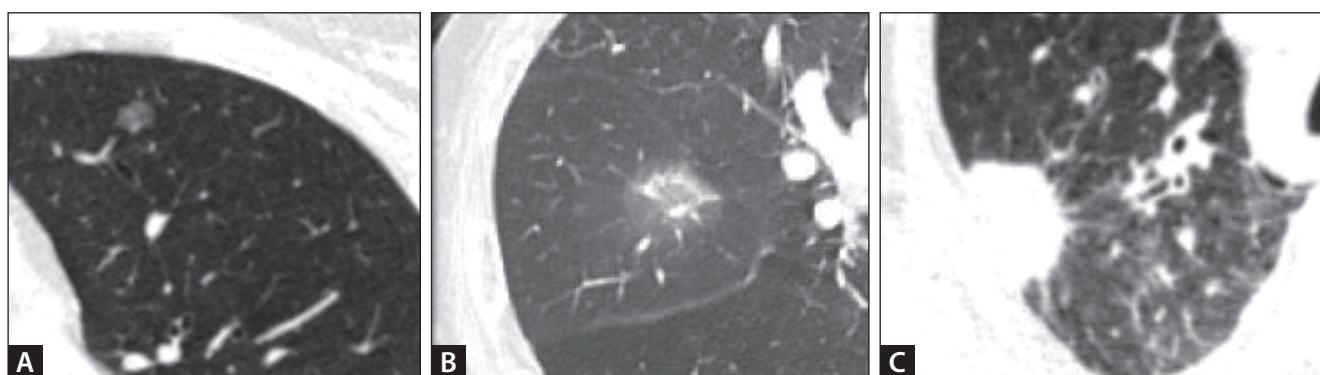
Computed tomography images of solitary pulmonary nodules. (A) Pure ground-glass nodule, (B) part-solid nodule, and (C) solid nodule.
